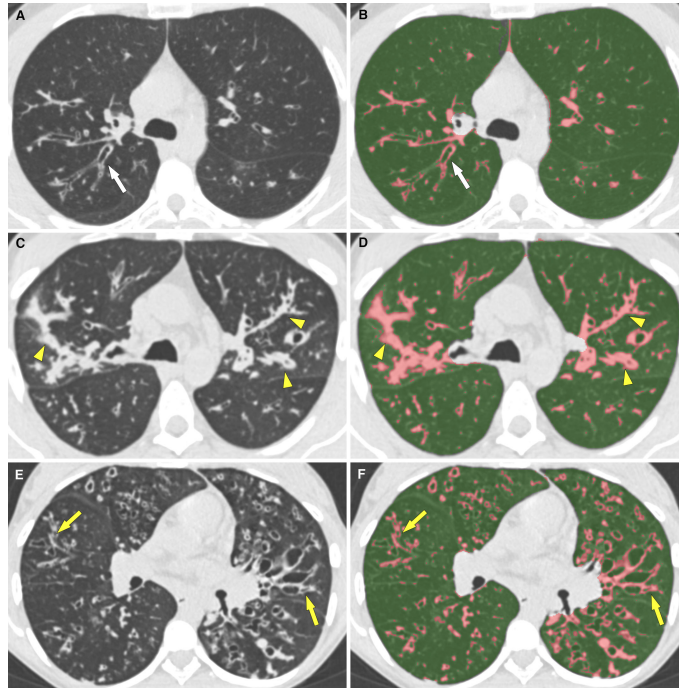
Automated CT scoring in patients of the validation cohort with various disease severity. (A) Axial CT image in a patient with mild lung disease (FEV1=77%). Bronchiectasis and bronchial wall thickening are seen in the posterior segment of the right upper lobe (white arrow). (B) Scoring with Mode+300 HU results in a CT-Density score of 4.4. (C) Axial CT image in a patient with moderate disease (FEV1=56%) shows bilateral mucus plugging (yellow arrowheads). (D) CT-Density score is 9.8. (E) Axial CT image in a patient with severe disease (FEV1=31%) shows diffuse bronchial bronchiectasis and bronchial wall thickening (yellow arrows). (F) CT-Density score is 14.5.
